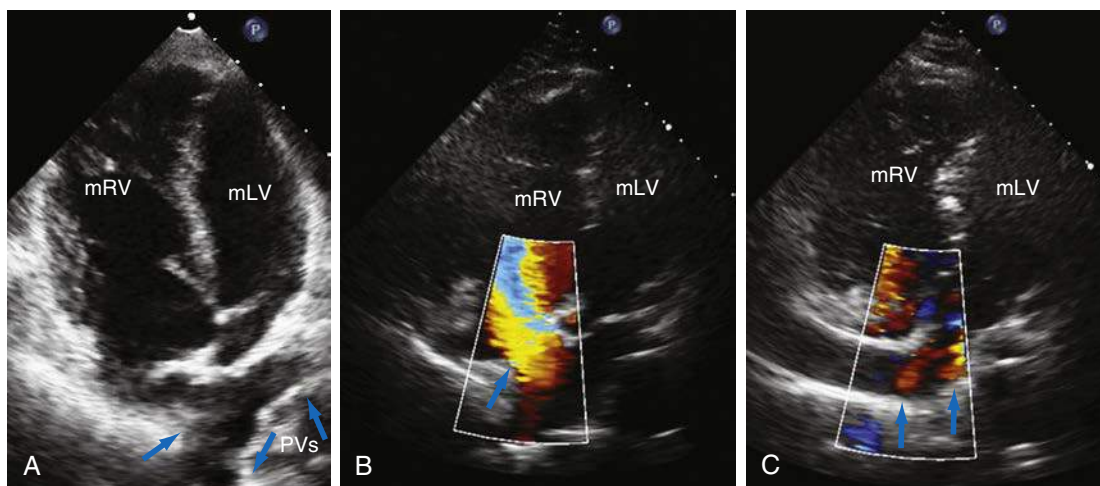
A, Two-dimensional transthoracic echocardiography of apical four-chamber view from a patient with transposition of the great arteries (TGA) after an atrial switch operation showing pulmonary venous blood redirected to the right ventricle (blue arrow). B, Color flow image showing blood flow from pulmonary veins being redirected to the right ventricle (blue arrow). C, Color flow image showing blood flow from inferior vena cava (IVC) baffle to the left ventricle (blue arrows). *mLV*, Morphologic left ventricle; *mRV*, morphologic right ventricle; *PVs*, pulmonary veins.
